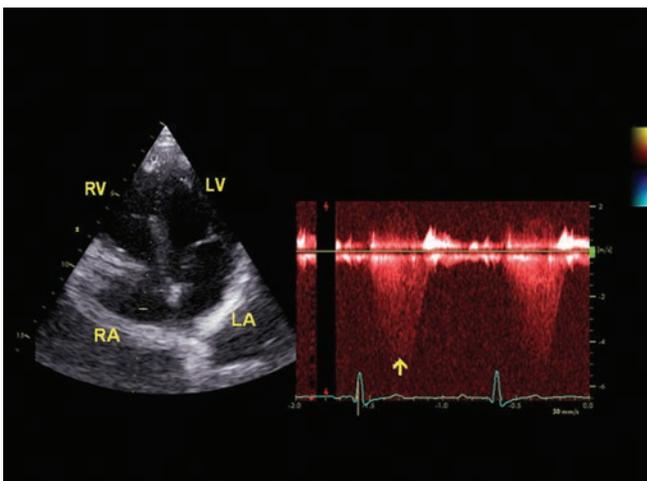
Continuous wave Doppler sampled along the right side of cardiac septum, apical 4-chamber view. (LA: Left atrium; LV: Left ventricle; RA: Right atrium; RV: Right ventricle).
